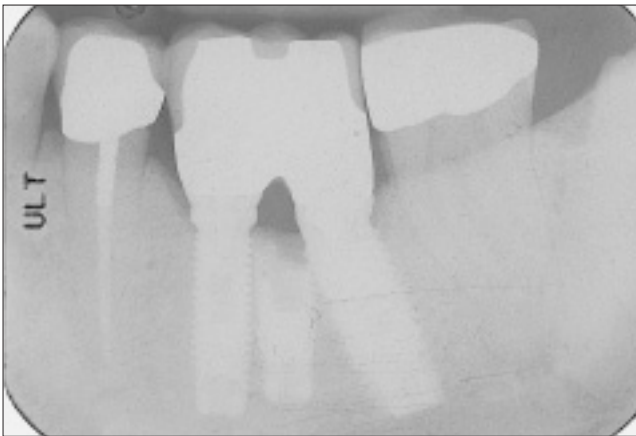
Periapical radiograph at 6.5-year follow-up. There is bone regeneration between the 2 functioning implants and above the sectioned implant.
